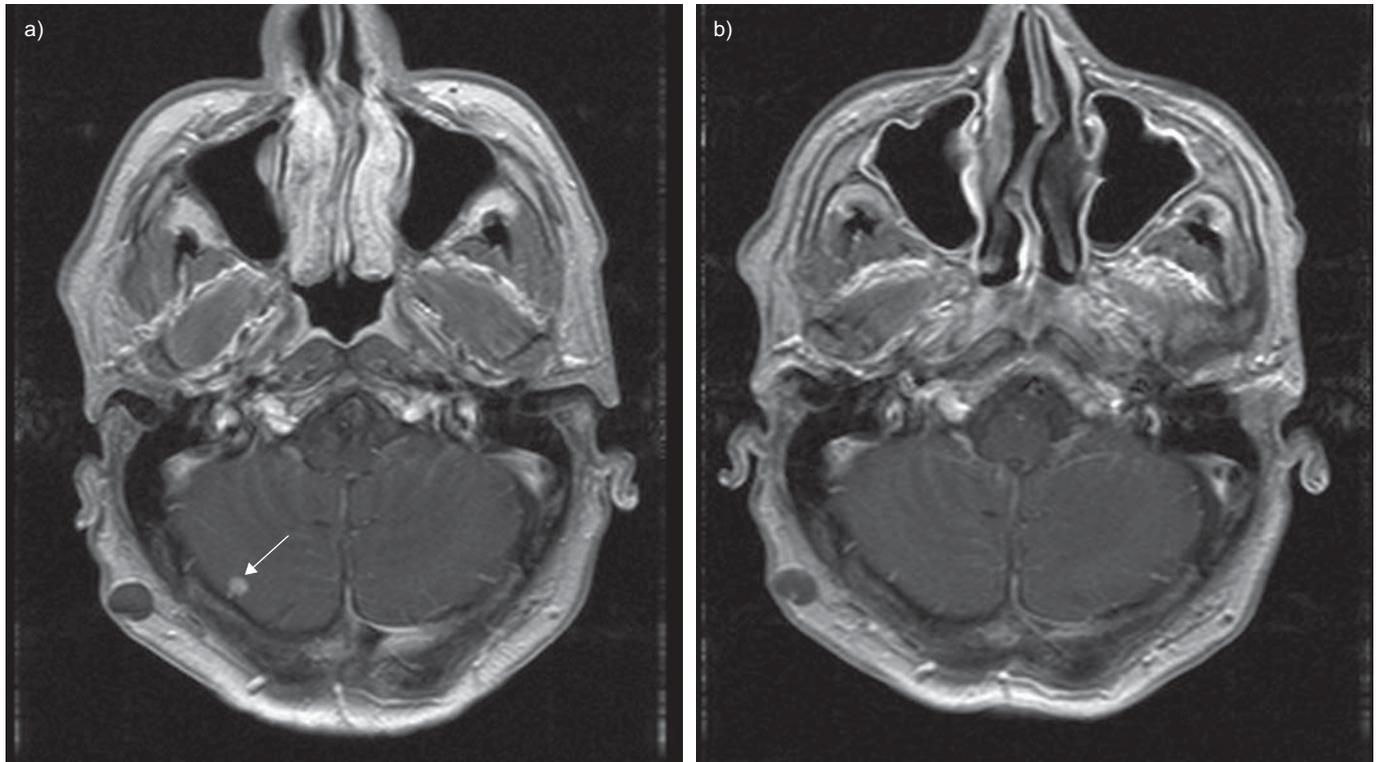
Brain magnetic resonance imaging. Axial T1-weighted image after contrast (Gd) administration of patient 5, a male with adenocarcinoma of the lung and a brain metastasis, harbouring exon 19 deletion. a) A brain metastasis in the right hemisphere of the cerebellum before initiating erlotinib (white arrow). A sebaceous cyst is seen into the right subcutaneous tissue. b) Complete response of the cerebellum metastasis after 4 months of treatment with erlotinib.
